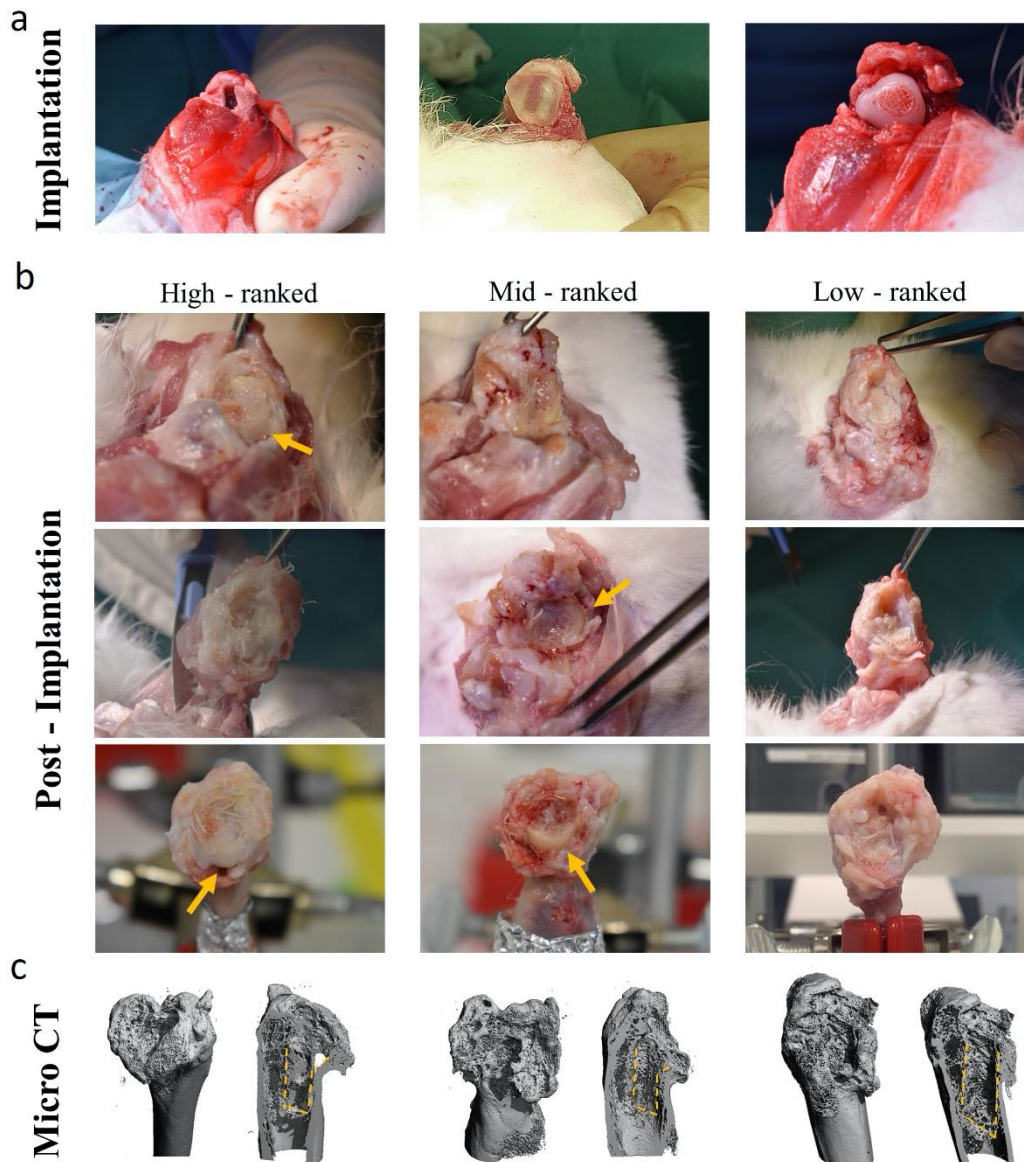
(a) Macroscopic images of the scaffold during implantation by press fitting into the medullary cavity. (b) Macroscopic evaluation of the operated joint post-implantation showing failure of the scaffold. The yellow arrows point to the repaired tissue. (c) Micro CT images showing mineralized tissue formed at the site of implantation, especially around the stem (yellow dashed line) of the scaffold.
